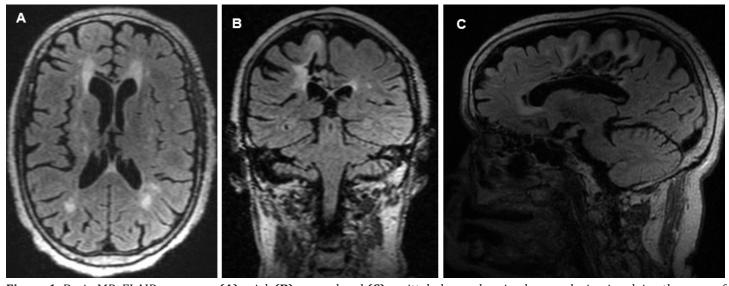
Brain MR, FLAIR sequence, (A) axial, (B) coronal and (C) sagittal planes showing lacunar lesion involving the genu of the corpus callosum with right side predominance and an extensive area of encephalomalacia in the corpus callosum involving the mid-body extending to the anterior cingulate cortex on the right side with sclerotic margins.
